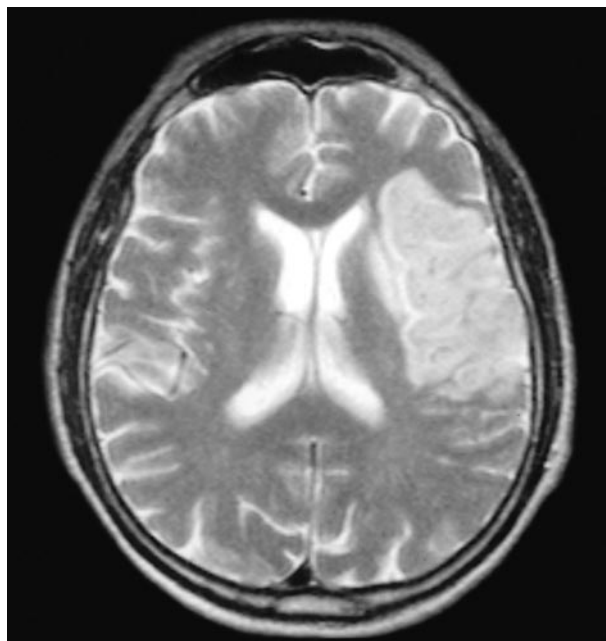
Axial T₂-weighted magnetic resonance imaging scan from patient 1 three days after his stroke showing increased signal in the left frontal and parietal lobes. Similar signal changes were seen in the left temporal lobe (not shown).
